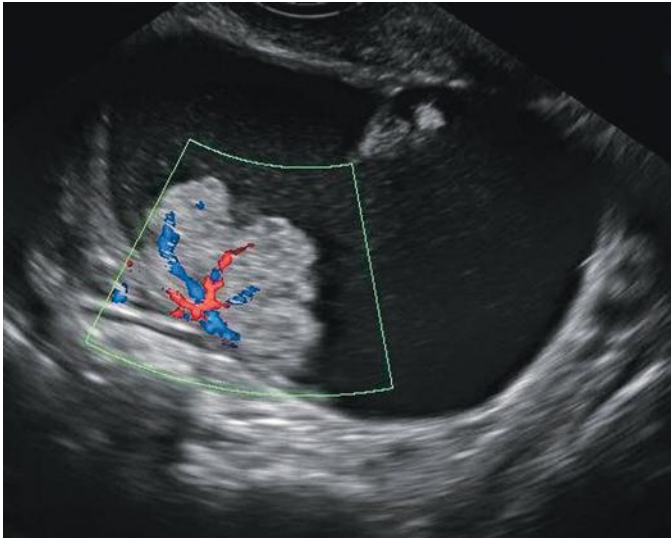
Borderline mucinous neoplasm. The predominantly cystic ovarian mass contains an irregular solid mural nodule that demonstrates internal flow on color Doppler interrogation.
